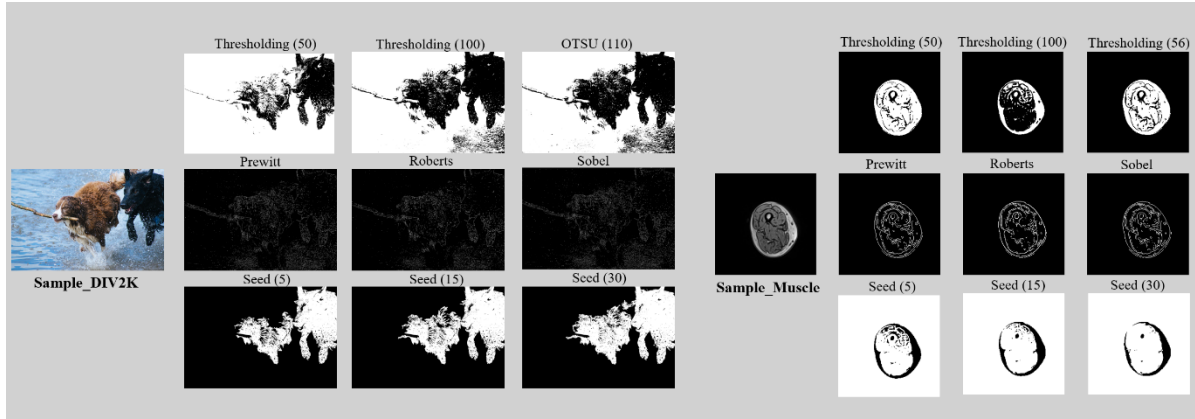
Visualization of segmentation based samples of a natural image from public dataset (DIV2K) and a human lower-limb MRI slice. For each case, the threshold method (threshold set to be 50/100 and automatically set using OTSU method), edge detection (three operators were used) and region-growing method (seed set to be 5/15/30) were used respectively.
